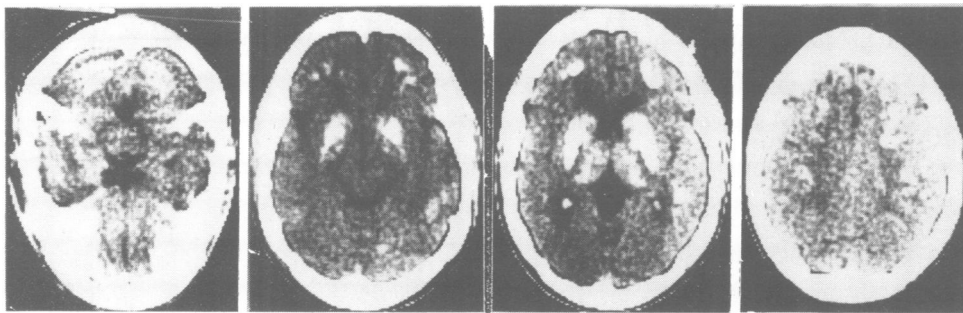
CT scan without contrast: calcification of basal ganglia, frontal, parietal and occipital lobes and cerebellum is seen on both sides.
